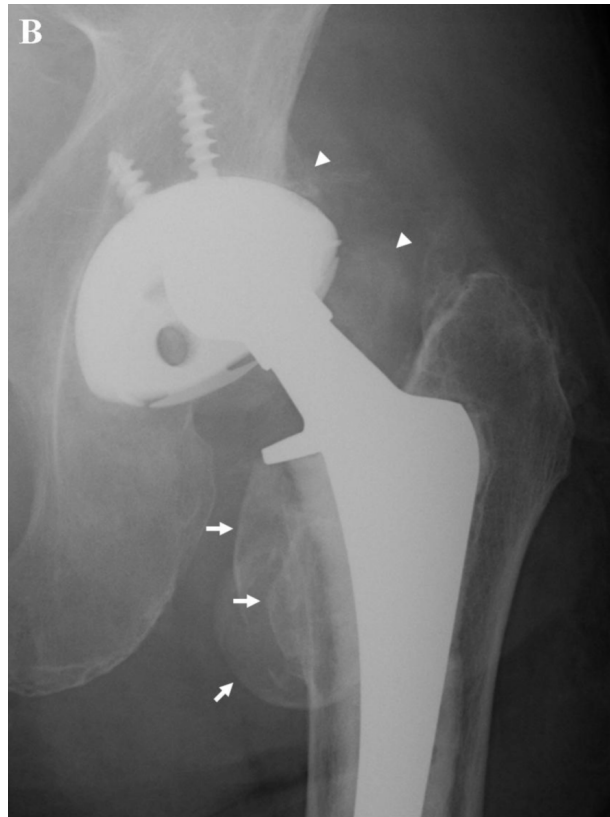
AP radiograph of the right hip shows eccentric position of the femoral head within the acetabular cup. The bubble sign (arrows) and cloud sign (arrowheads) are present in the periprosthetic region of the left hip joint.
